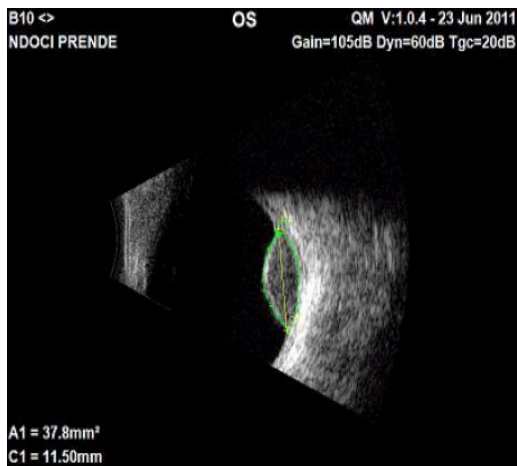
Ultrasound of the left eye
